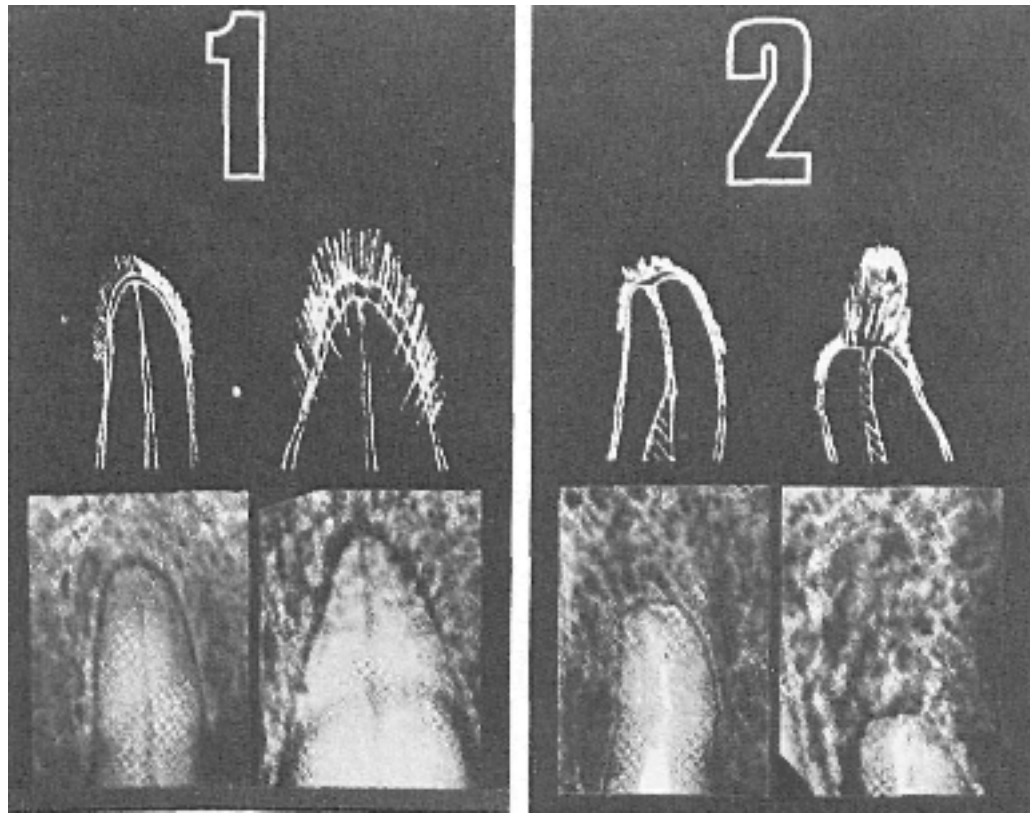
PAI reference classification 1 and 2 ( From “The periapical index: a scoring system for radiographic assessment of apical periodontitis.” Orstavik et al. 1986 )
